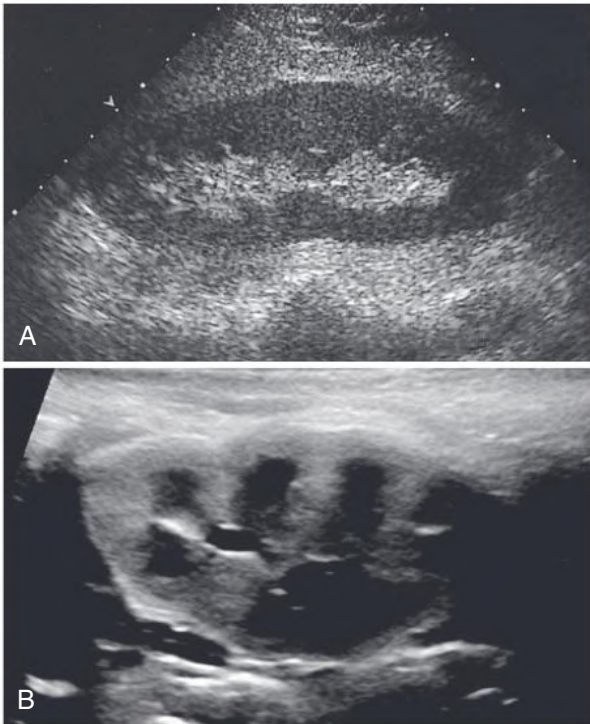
Ultrasound Images of Kidney. (A) Normal sagittal renal ultrasound image. The cortex is hypoechoic compared with the echogenic fat containing the renal sinus. (B) Normal renal ultrasound image in an infant. Note the hypoechoic pyramids.
